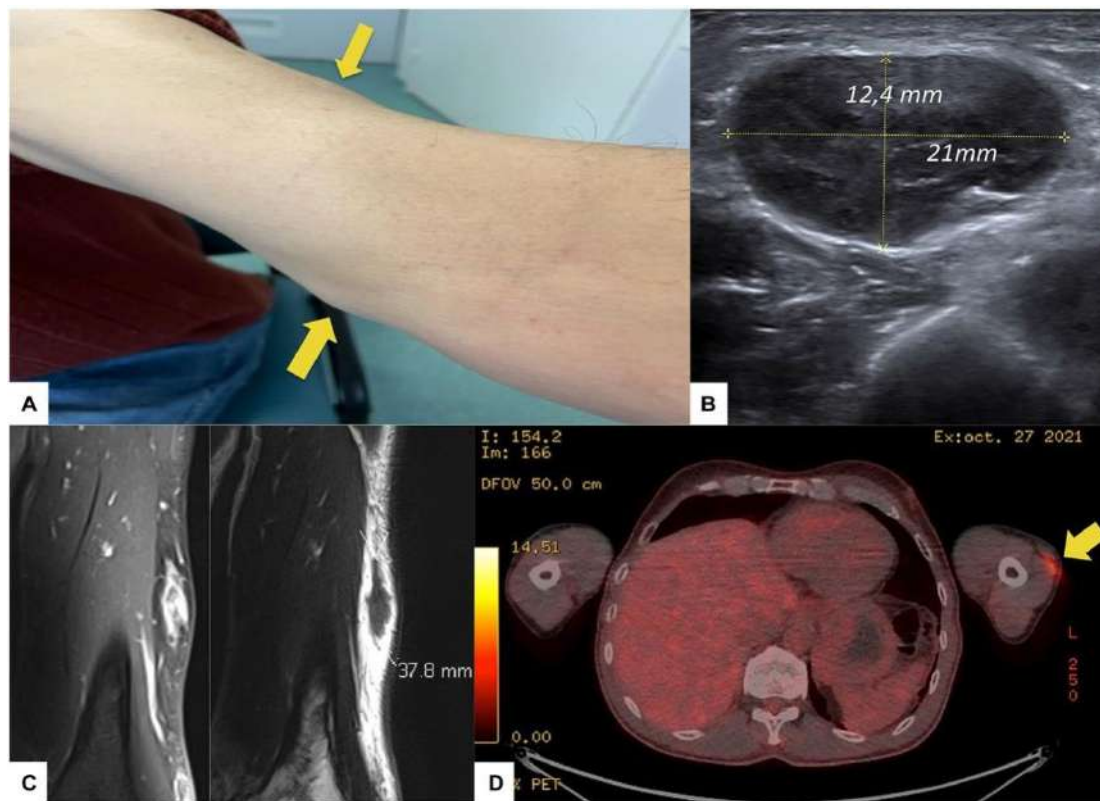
Clinical and paraclinical features of the patient under insulin therapy showing amyloid deposition (A) Two subcutaneous nodules on the left arm (arrows), (B) Ultrasound of the soft tissue of the left arm depicting one subcutaneous mass, (C) left upper limb MRI frontal slices of the (T1 with gadolinium injection on the left, and T2 on the right), and (D) 18-FDG-PET-CT scan of the left arm nodule considering a 18-FDG uptake (arrow) *Fig adapted from Dubernet A. et. al, 2023, Front. Med., <https://doi.org/10.3389/fmed.2023.1064832>*
